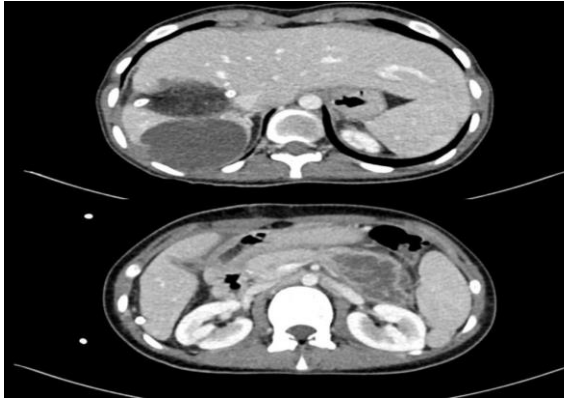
Contrast enhanced CT showing fluid attenuated area along resected margin in segment VII.
